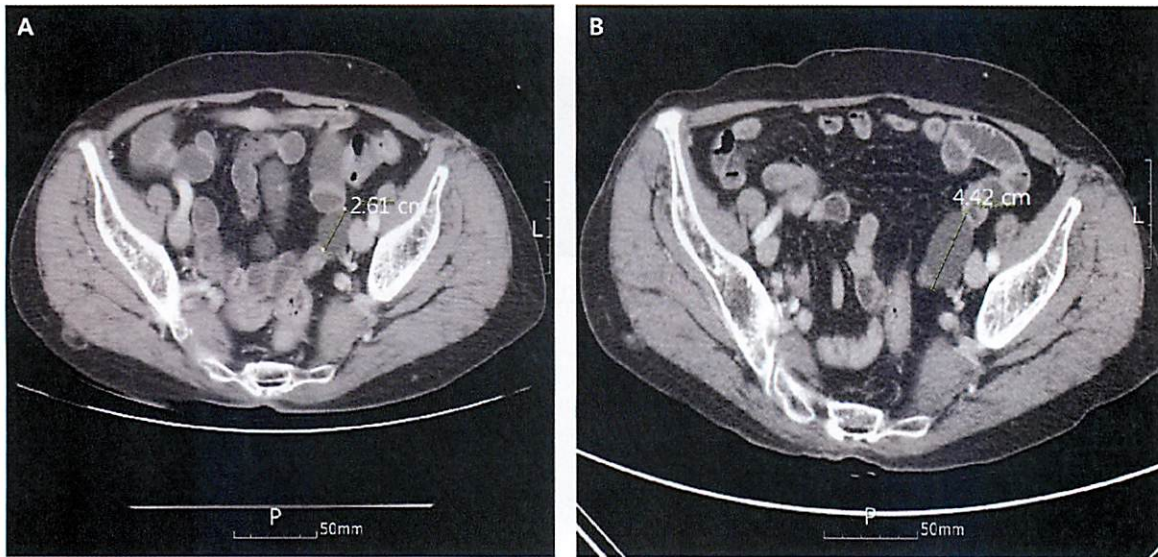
Abdominal-pelvic CT demonstrates enlargement of left adnexal cystic mass (bar) from 2.61 cm (A) to 4.42 cm (B) over a 1-year period.
